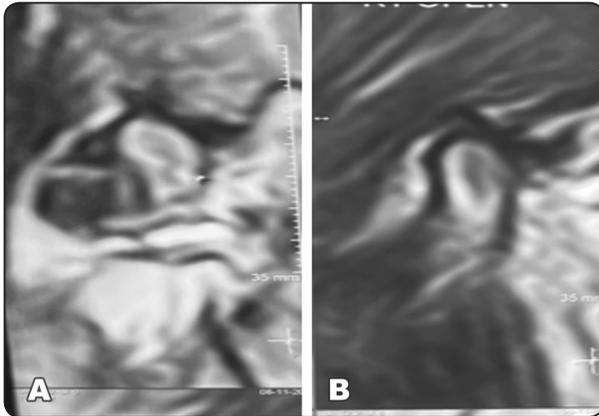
MRI T2 weighted images in open mouth positions show A) anterior meniscal displacement, B) internal derangement with steepening of eminence anterior to disc with narrowing of space to disc movement
